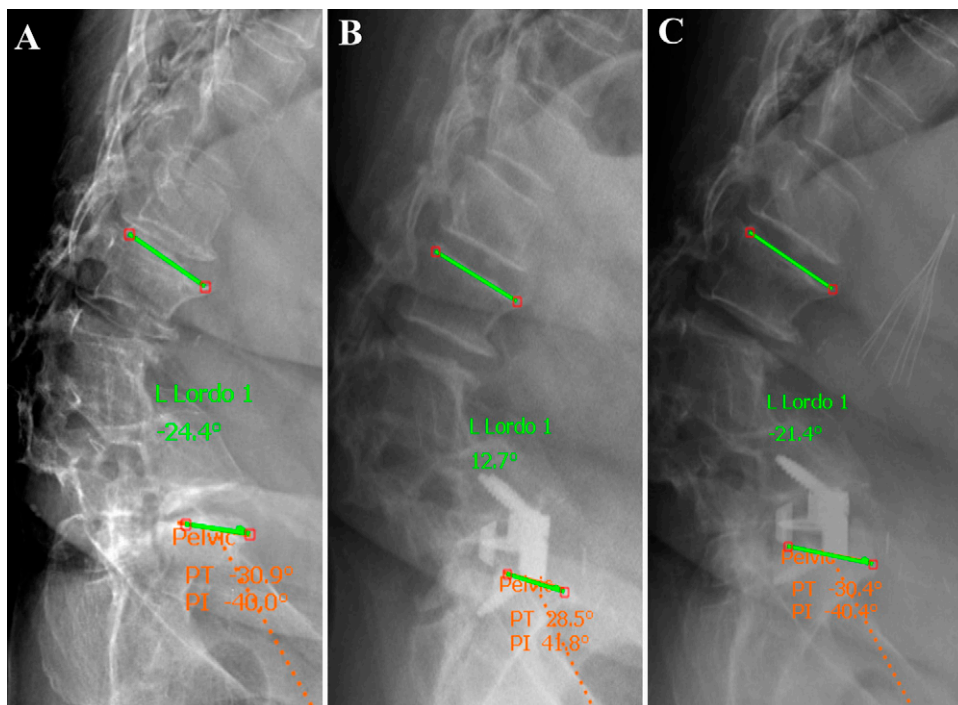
A: Preoperative sagittal scoliosis radiograph. LL of -24.4° , PI of 40.0° , and PI-LL mismatch of 64.4° . B: Postoperative upright radiograph. LL of -12.7° , PI of 41.8° , and PI-LL of 54.5° . C: One-year follow-up scoliosis radiograph. Some regression of lordosis with LL of -21.4° , PI of 40.4° , and PI-LL of 61.8° .
